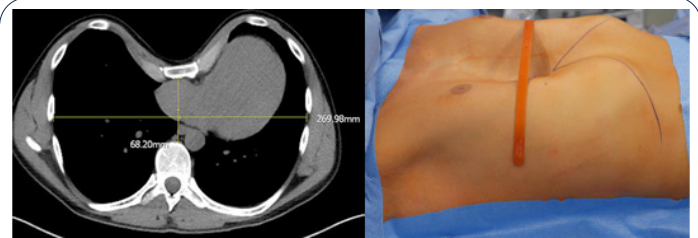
(A) CT-scan of the chest with severe pectus excavatum deformity. (B) Topographic demonstration of the pectus excavatum deformity.
